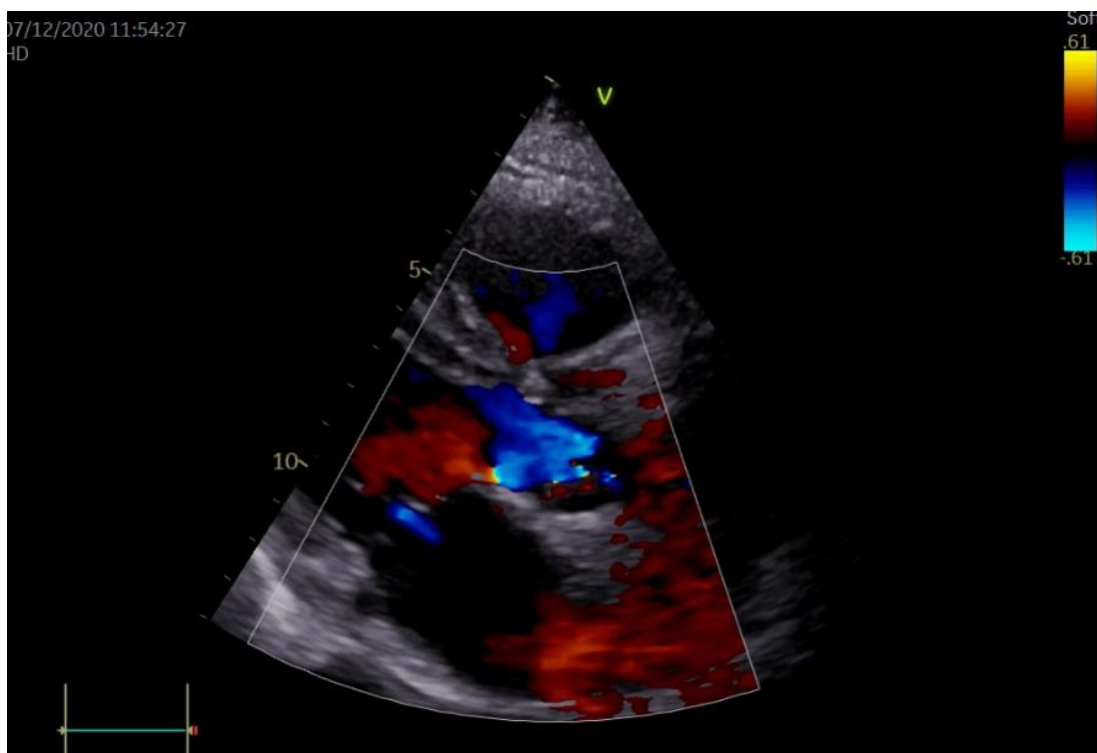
Color Doppler image
